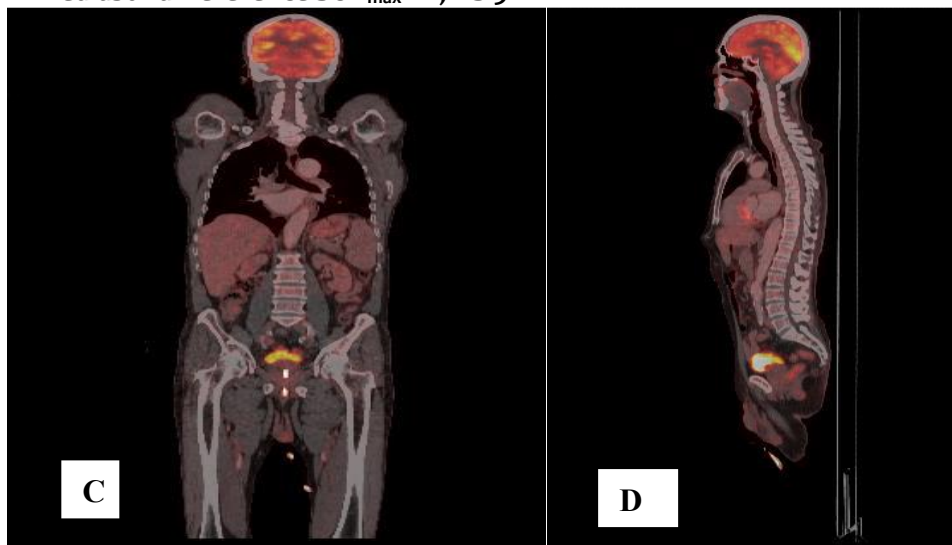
C, D. are Post-Therapy Negative PET/CT Scan for the same patient showing the following observations: Complete metabolic remission of supra/ infra-diaphragmatic lymphadenopathies. No newly developed metabolically active nodal or extra-nodal lesions. DS 1
